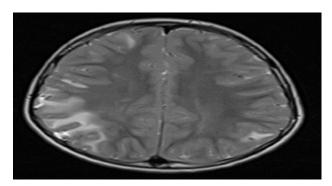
MRI brain T2W axial image showing hyper intensities along subcortical white matter suggesting edema.
